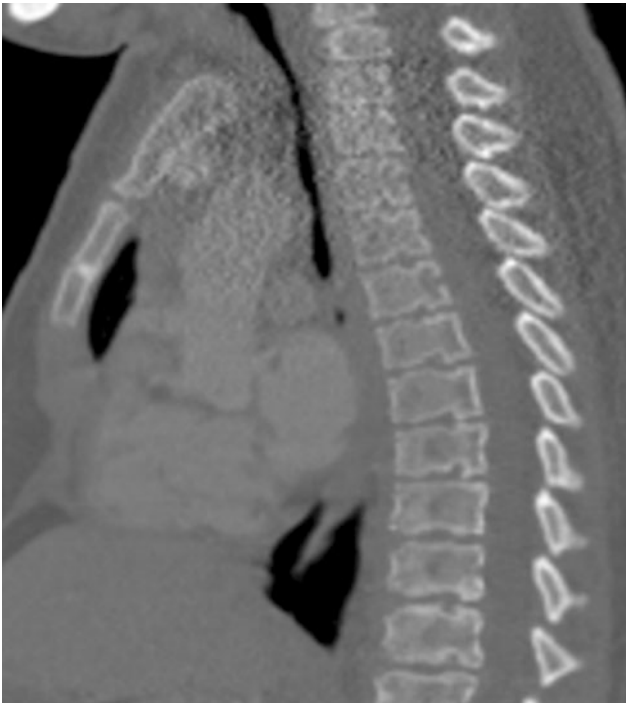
Mucopolysaccharidosis (MPS). A sagittal chest CT image reconstructed with bone windows in a 16-year old with Type 2 MPS (Hunter syndrome) shows severe narrowing of the intrathoracic tracheal lumen and spinal dysostosis. Airway obstruction results from a narrowed thoracic inlet and accumulation of glycosaminoglycans in the airway wall
